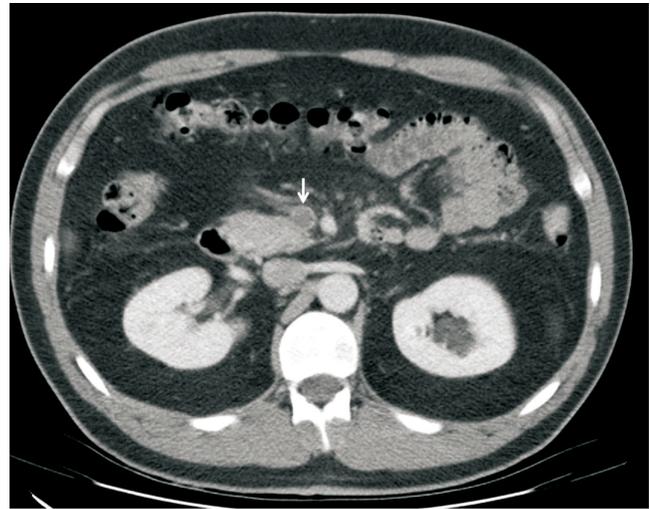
CT showing enlarged superior mesenteric vein with low-attenuation central filling defect, representing acute mesenteric thrombosis.
